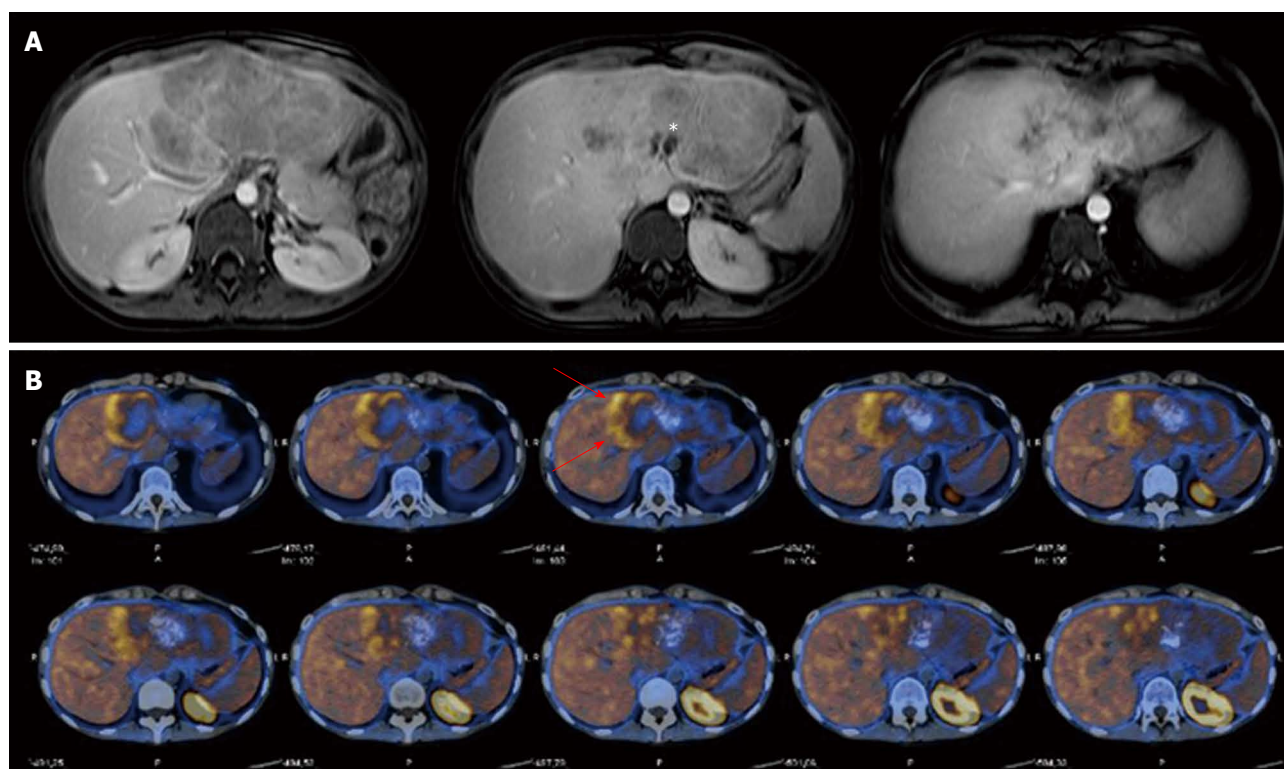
Radiological imaging. A: Abdominal magnetic resonance imaging scan showing a 16 cm diameter inhomogeneous and partially calcified (asterisk) mass of the left liver; B: Total-body ^{11}C -choline positron emission tomography showed a slight pathological uptake of the tracer in the peripheral part of the tumour (red arrows).
